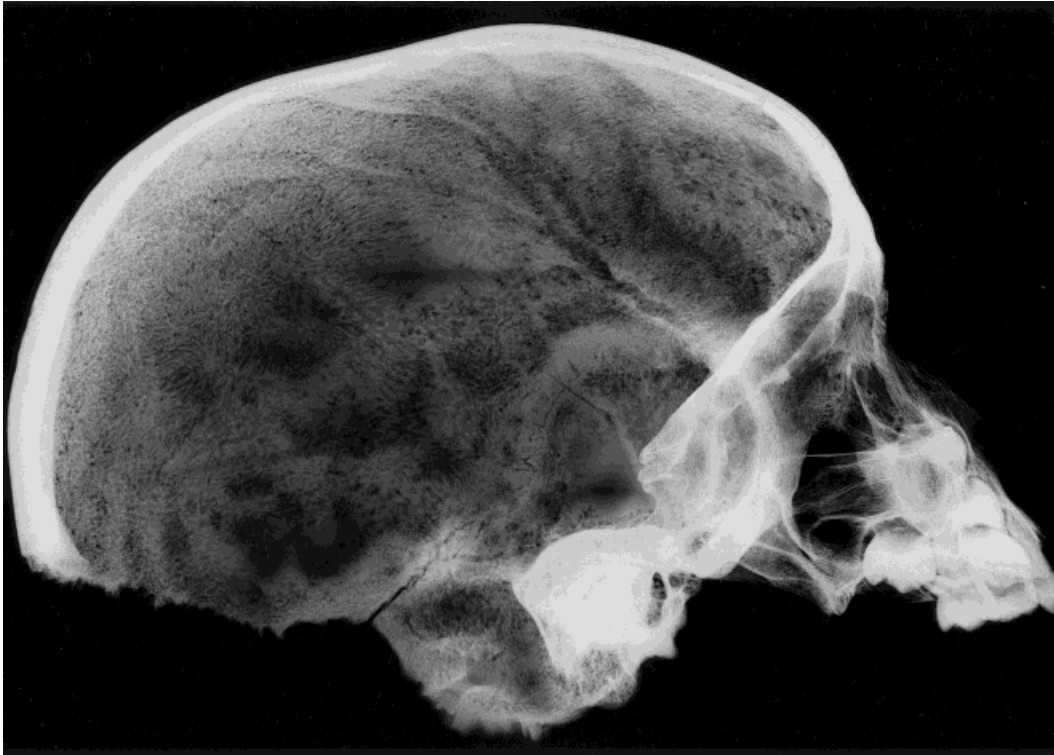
Lateral skull (HTH 1115) radiograph. Mild frontal intradiploic plate tunneling. Generalized bone resorption with minimal disruption of internal diploic plate. Parallel arrangement of residual trabeculae, producing swept-back coiffeur appearance.
